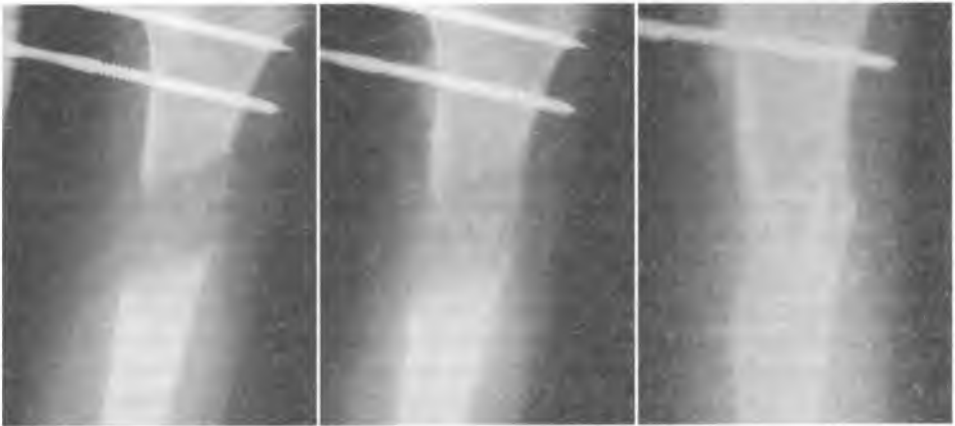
Radiographs of the right femur of 17 years old boy. Before the first application of PRP (A), 4 weeks later after (B), and 10 weeks after application of PRP (C). Callus formation was satisfactory during the lengthening period
